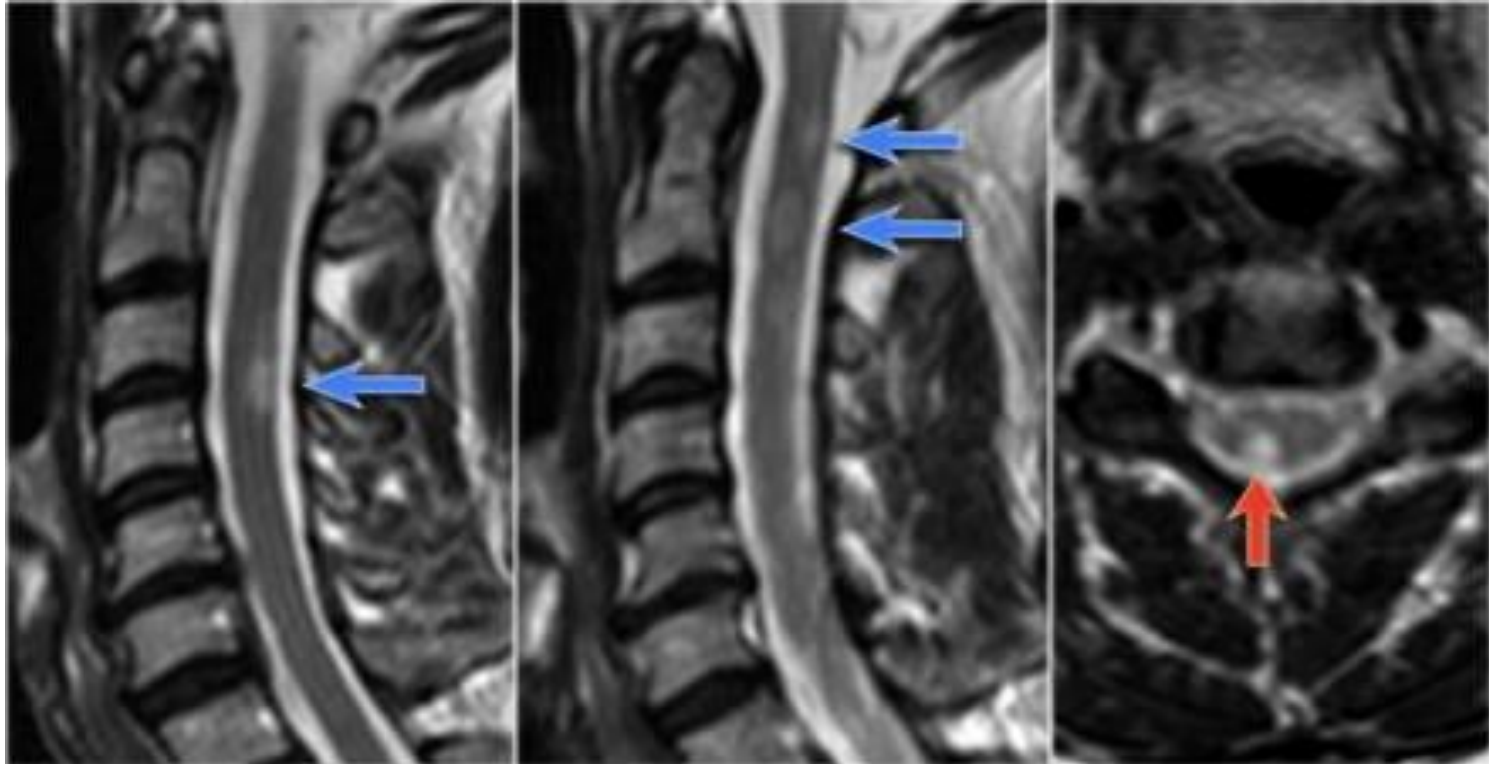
40.8 T2-WI sagittal MRI of cervical spine demonstrate extending from mid-c2 to mid-c3 (between arrows) and mildly expanding the cord (a). The demyelinating lesion is hyperintense on the contrast enhanced sagittal T1-weighted image (b). On an axial T2-weighted image at the mid-C2 level round or triangular shape and are located posteriorly or laterally is involved and shows a hyperintense signal (c) suggesting MS
